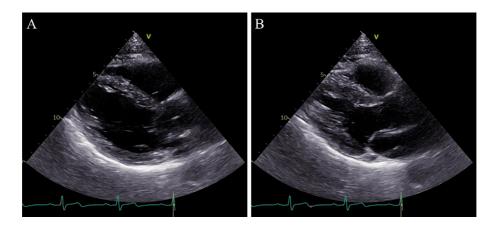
Transthoracic echocardiography after steroid treatment (parasternal long-axis view; A: end-diastolic phase, B: end-systolic phase)
